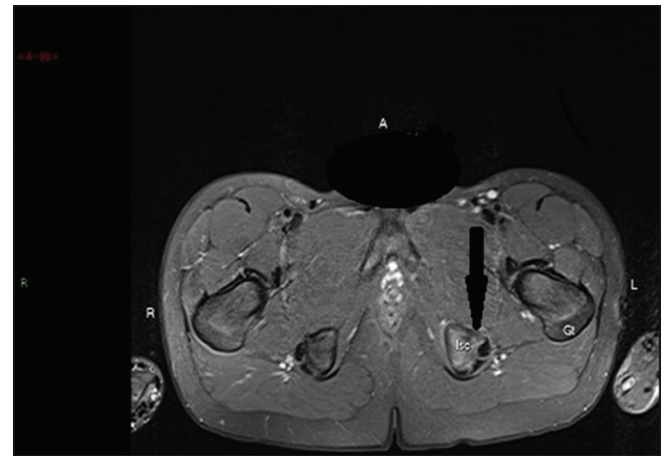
Axial T-2 weighted magnetic resonance imaging at the level of the ischium (black arrow) showing improvement at the left ischium
